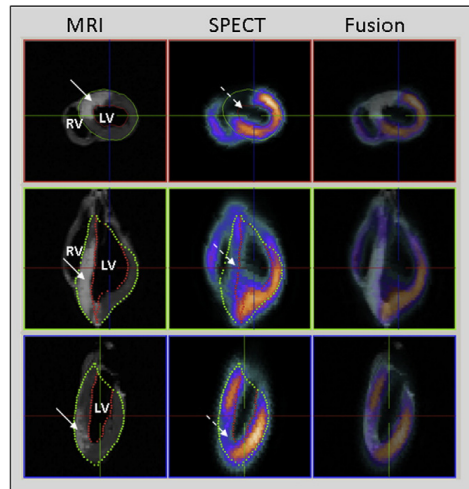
Imaging of myocardium at risk and final infarct size after experimentally induced ischemia by occluding the left anterior descending coronary artery. Left column: Magnetic resonance imaging (MRI) performed for visualization of the anteroseptal infarction (solid arrows). Dark gray myocardium indicates viable myocardium and white indicates infarction. Middle column: Single photon emission computed tomography (SPECT) used to assess the myocardium at risk by visualization of the anteroseptal perfusion defect (dashed arrows). Warm colors indicate adequate perfusion and cold/absent colors indicate decreased/lack of perfusion. Right column: Fusion of MRI and SPECT images. The upper panel shows a mid-ventricular short-axis slice and the lower two panels show two long-axis slices. Endocardial and epicardial borders of the left ventricle were manually delineated in the MR images and fused with the co-registered SPECT images. LV = left ventricle, RV = right ventricle. (From Demidova et al. J Electrocardiol 2011; 44 (1):74-81).
